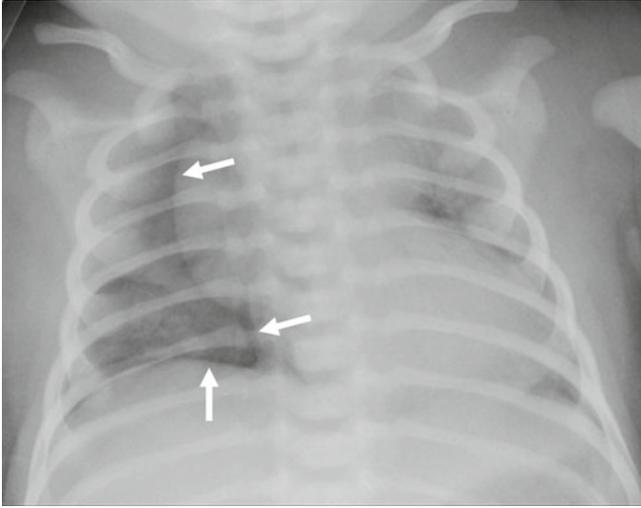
Pneumothorax. Right pneumothorax. Supine chest radiograph shows a sharp right mediastinal borders and diaphragm (*arrows*). The pneumothorax is predominantly medial and anterior in location
